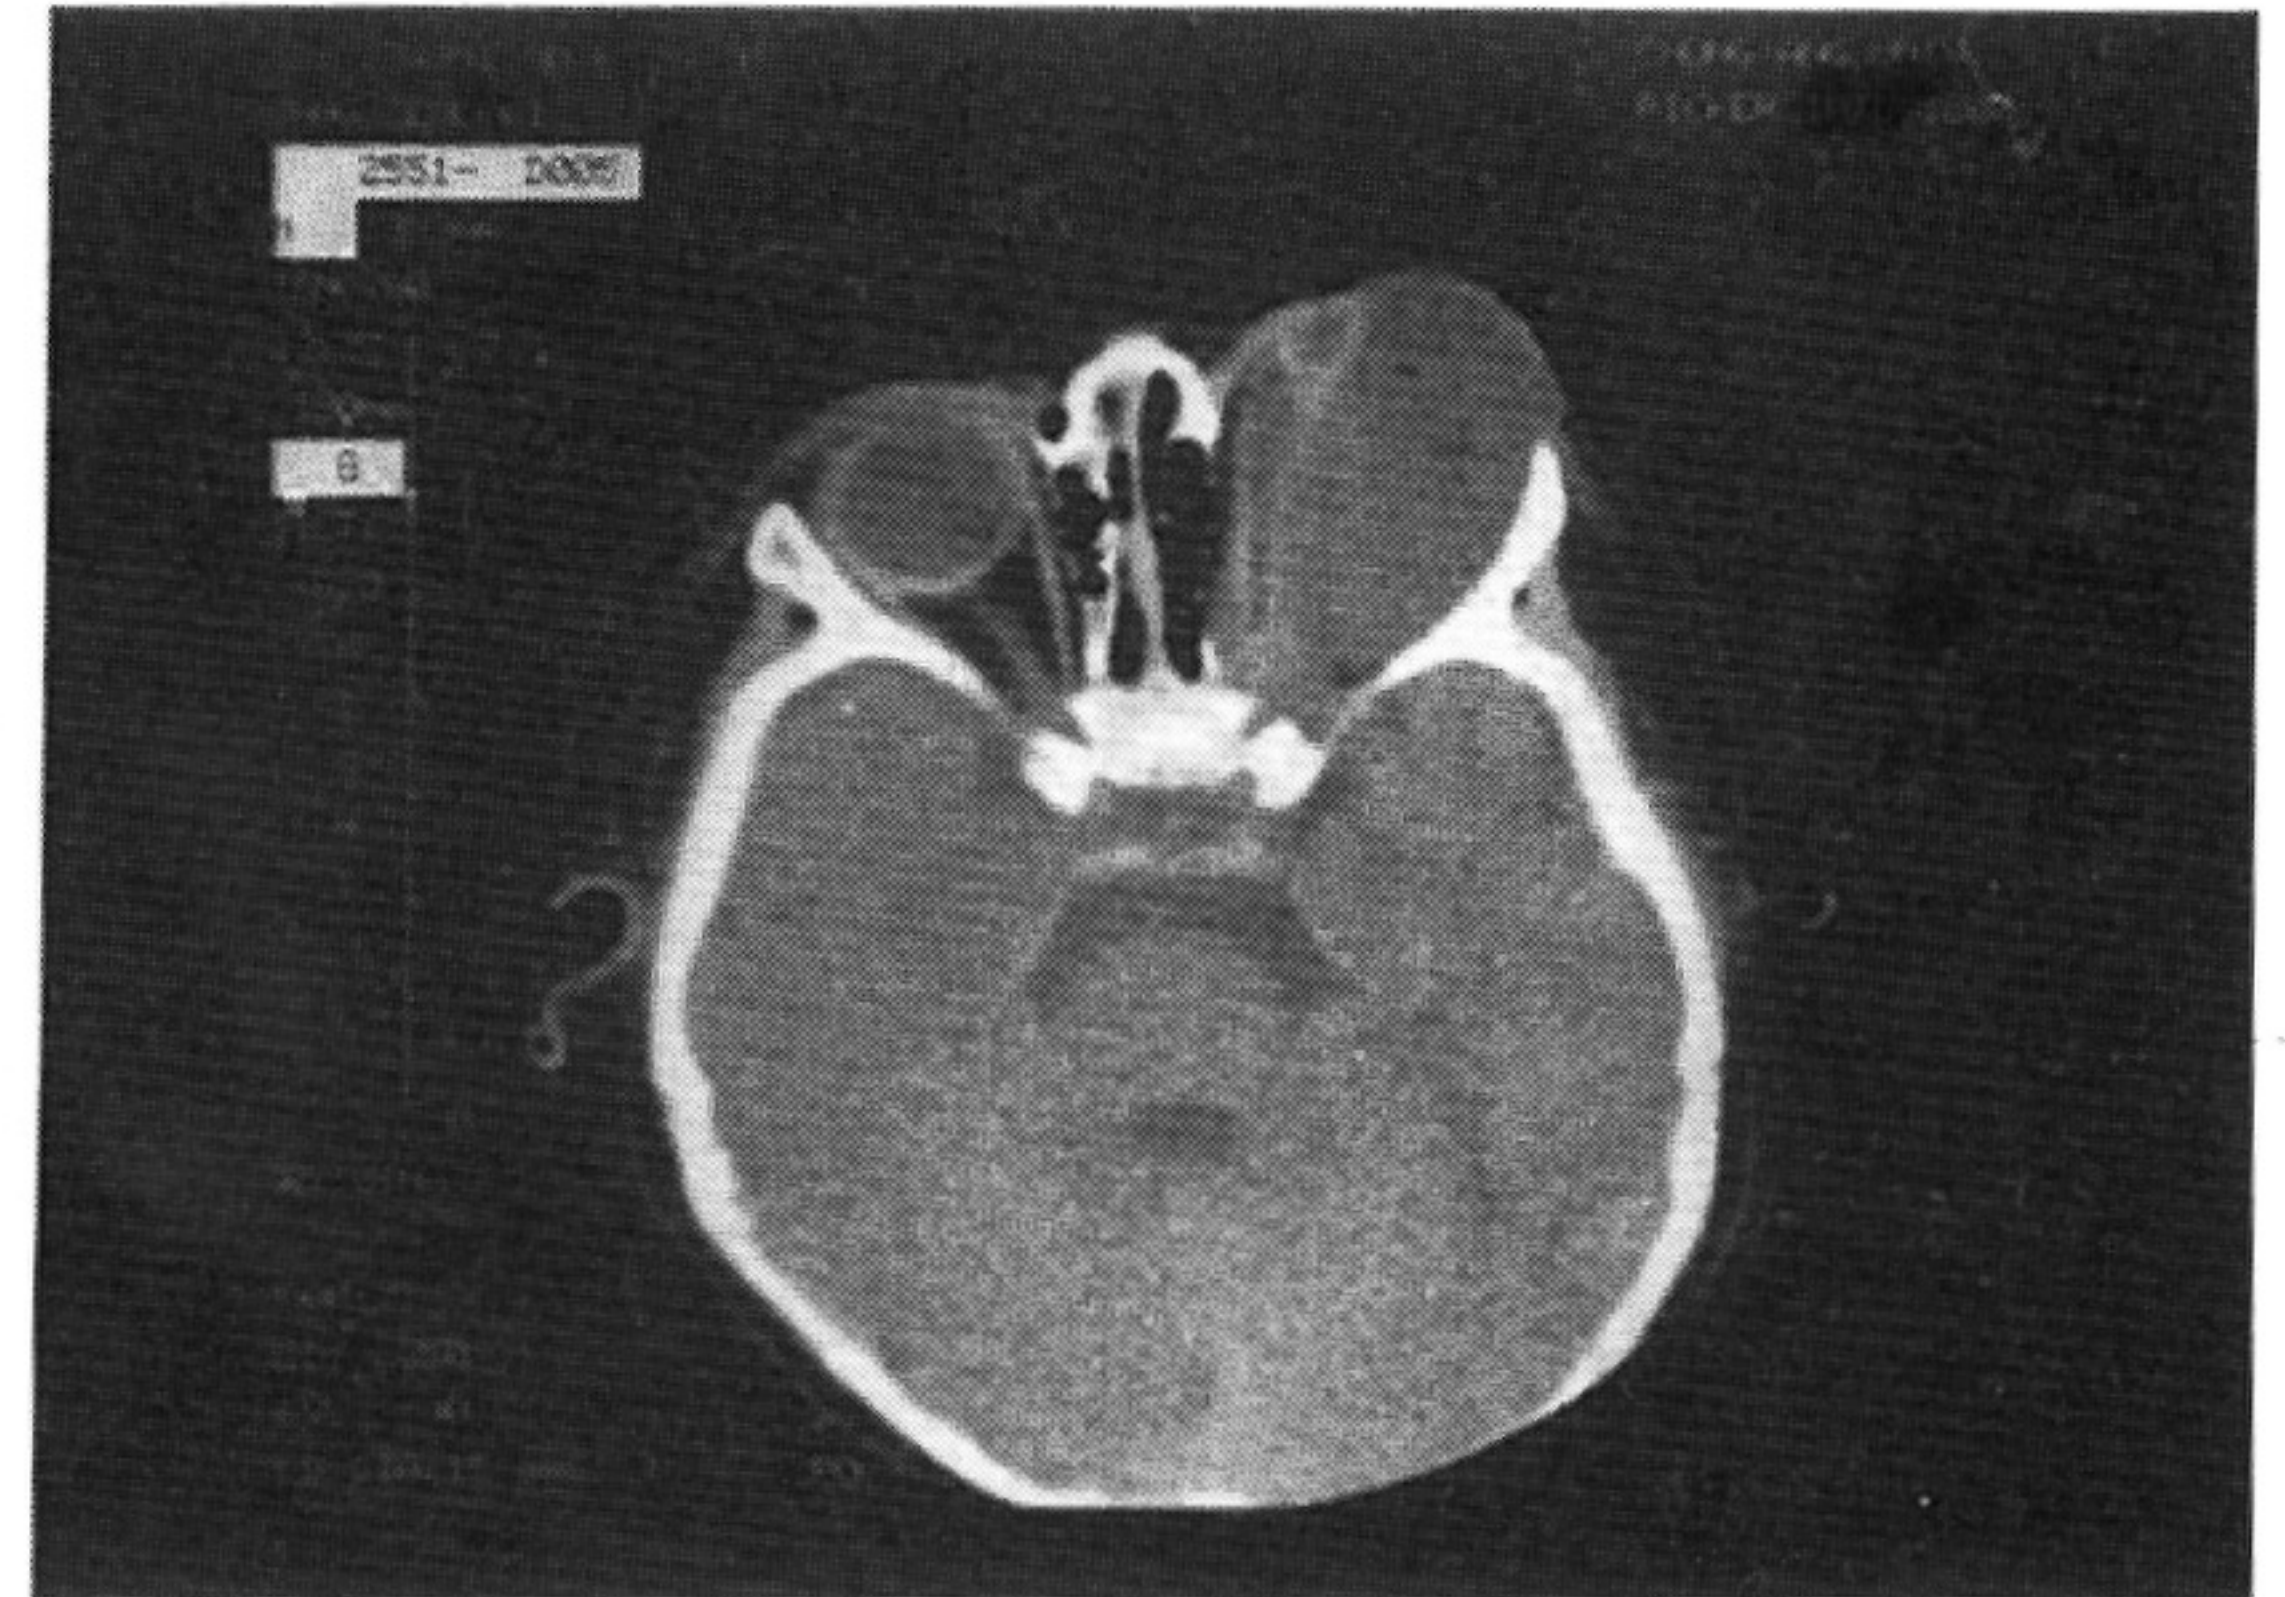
Computed tomogram of the orbit shows a large cyst with medially displaced microphthalmic eyeball occupying the entire left orbit. An extraocular muscle attaches to the microphthalmic eyeball medially.
